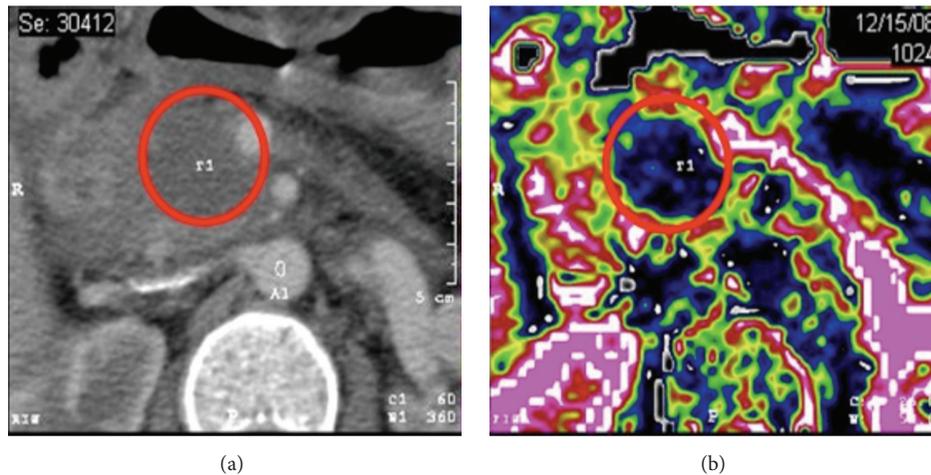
(a) Preoperative CT-scan of a locally advanced pancreatic cancer. (b) Post-RFA perfusion CT-scan, showing a postablative area of decreased perfusion within the head of the pancreas. Copyright Chirurgia del Pancreas Verona.
